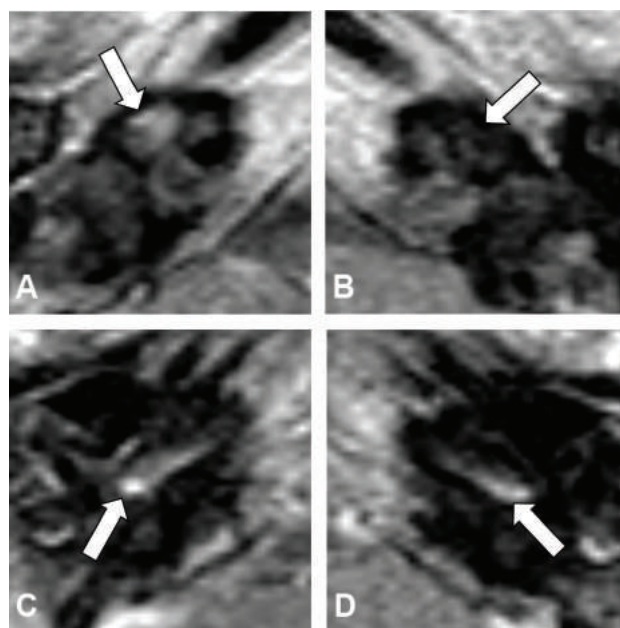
Case with partial cochlear enhancement of the basal turn (Patient 4). Axial gadolinium enhanced T1-weighted MRI which shows slight cochlear enhancement of the right apical turn (A), the left apical turn showed no enhancement (B). Enhancement of the basal turn was present on both the right side (C) and the left side (D). The ABR responses of the left ear showed repeatedly a hearing threshold of 60dB in the high frequencies. Therefore it was decided only to perform cochlear implantation on the right side; the contralateral left side was treated with a hearing aid hearing follow-up. In the non-enhancing part of the cochlea, hearing remained stable.
